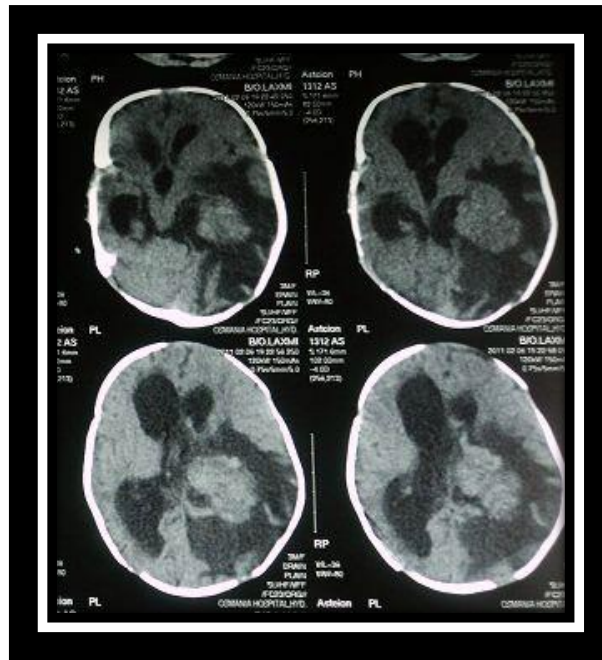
MRI showing mass lesion in the lateral ventricle
